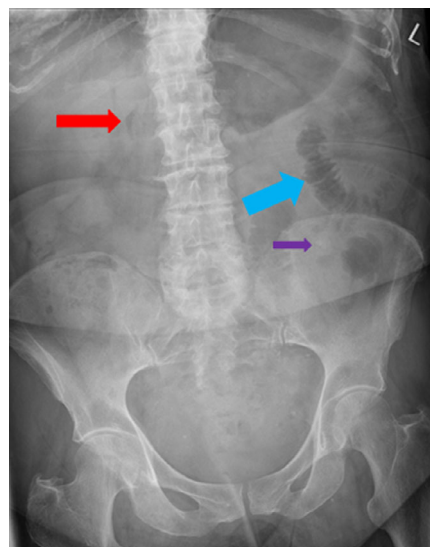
Plain abdominal radiograph demonstrating Rigler's triad
